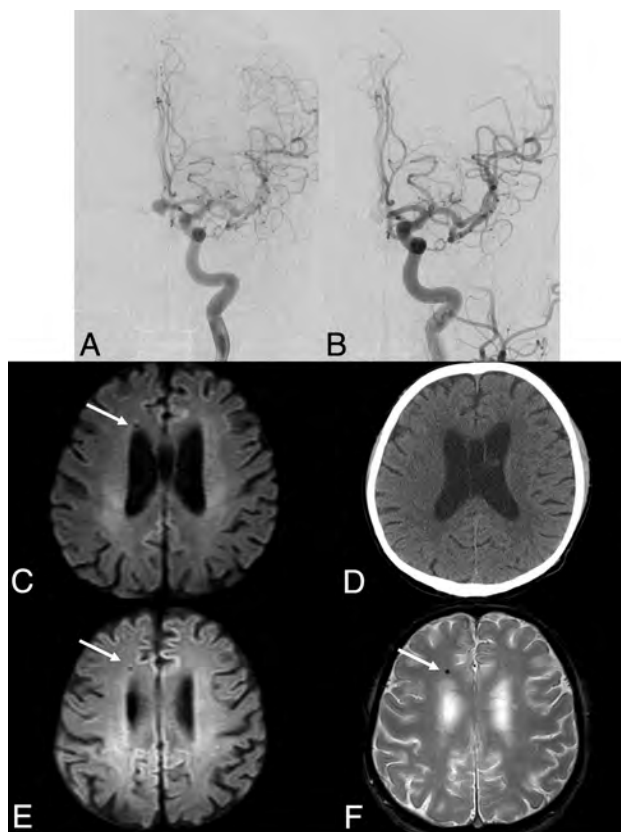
An anterior communicating artery aneurysm in case 5 (A) is embolized by using multiple coils (B). Postprocedural DWI shows an abnormal low-intensity spot with a hyperintense halo (white arrow) in the right frontal lobe (C), which is undetectable on the postprocedural CT (D). Follow-up MR imaging obtained 3 years after the procedure shows that the lesion remains without any signal changes (E and F).
